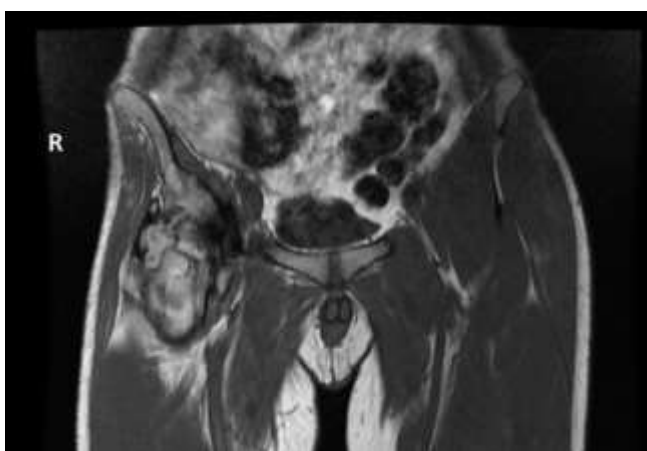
MRI section – April 2021
